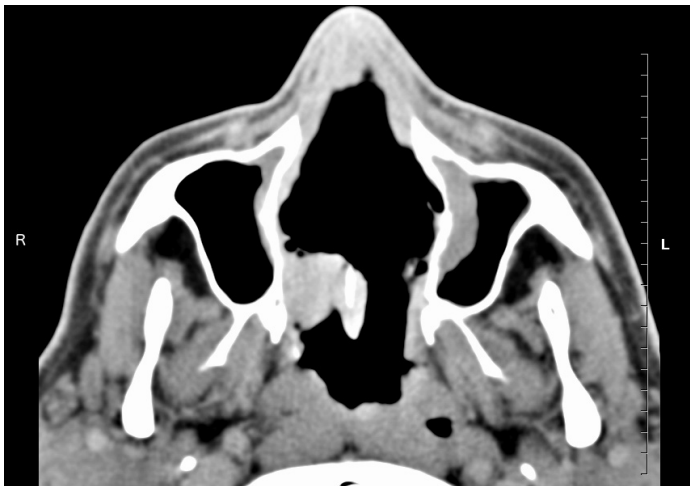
Axial CT image of the nasal cavity showing the soft tissue and bony loss of the nasal walls and septum.
